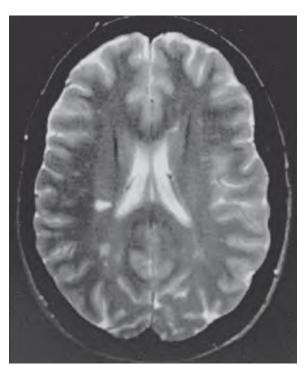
T2-weighted magnetic resonance image in a patient with Lyme disease reveals areas of increased signal intensity in the cerebral white matter.
